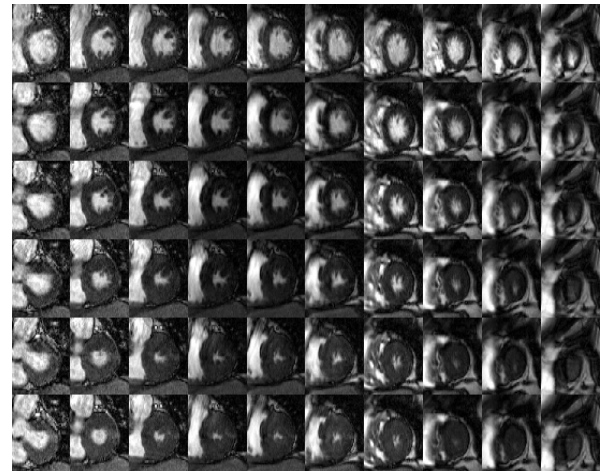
The MRI Cardiac Data of a Volunteer.
